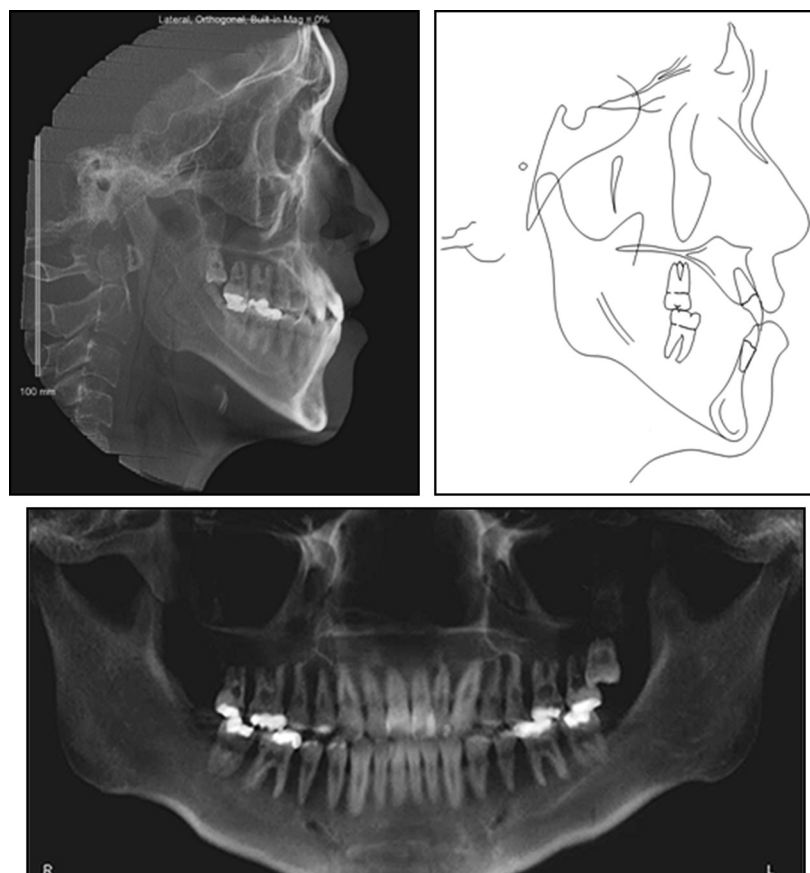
Initial orthogonal lateral cephalometric radiograph, cephalometric tracing, and panoramic radiograph.
